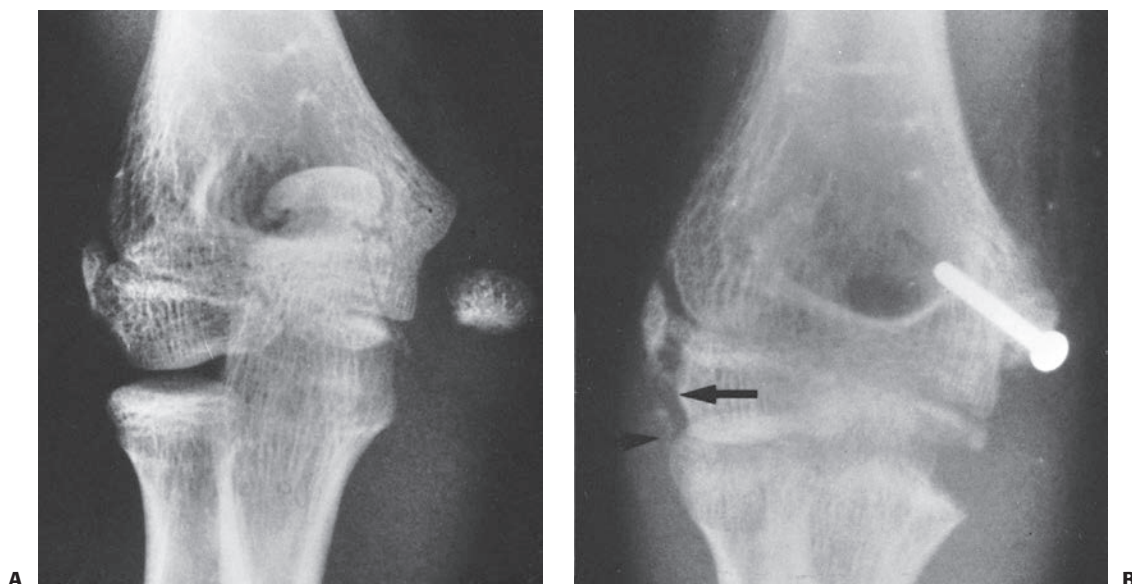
Operative stabilization. A: Injury film in a 12-year-old gymnast. Although this was a non-dominant extremity, it was thought that both elbows needed stability. B: Radiographs taken 4 weeks post-operatively show stabilization of the fragment with a single screw. There was also calcification of the lateral ligaments (arrows), confirming that the elbow was probably originally dislocated as well. (From Wilkins KE. Fractures of the medial epicondyle in children. *Instr Course Lect.* 1991;40:1–8, with permission.)
